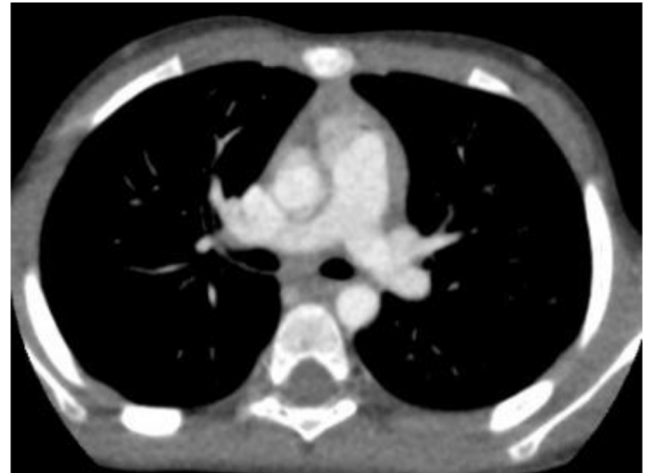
Source image of one of the CT volumes used to create the dynamic airway assessment for figure 1 to demonstrate the vascular anatomy in the conventional way.
